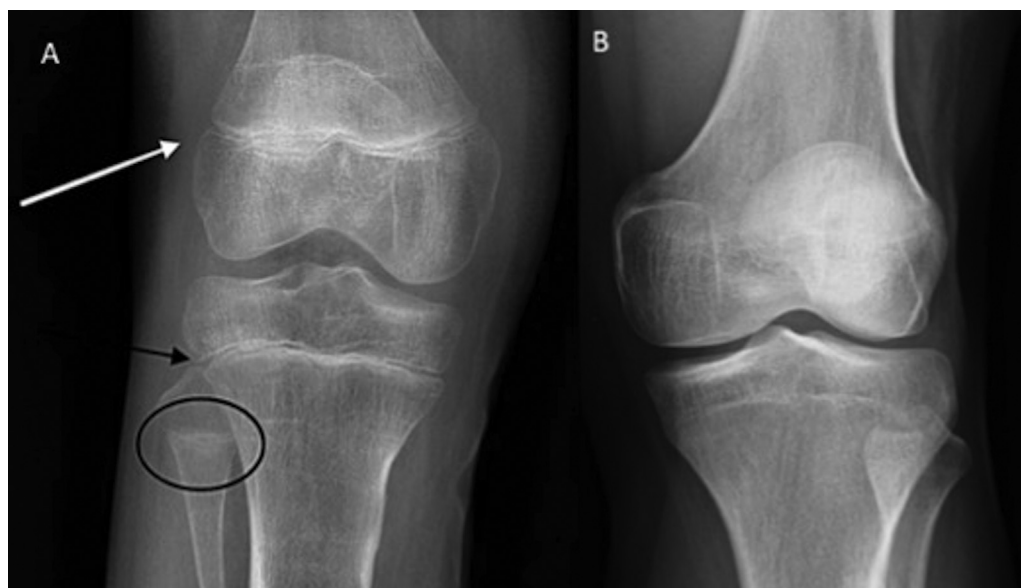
Anteroposterior view of knee joint radiographs showing (A) unfused epiphyses of lower end of femur (white arrow), upper end of tibia (black arrow), and fibula (black circle) and (B) fused epiphyses in these areas in another man indicating age more than 18 years.
